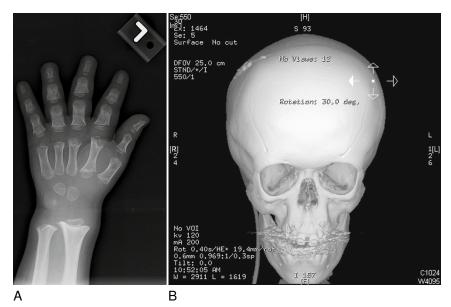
A, Bone age radiograph of a 3-year-old demonstrating an abnormal flared appearance of the metaphyses and shortened, broad phalanges consistent with achondroplasia. B, Three-dimensional reconstruction of computed tomography scan demonstrating midface hypoplasia typical of achondroplasia. (From The Ohio State University Wexner Medical Center, Columbus, Ohio.)
